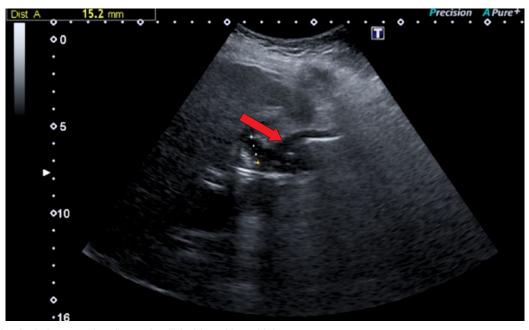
Abdominal ultrasound: collapsed gallbladder with multiple stones.
